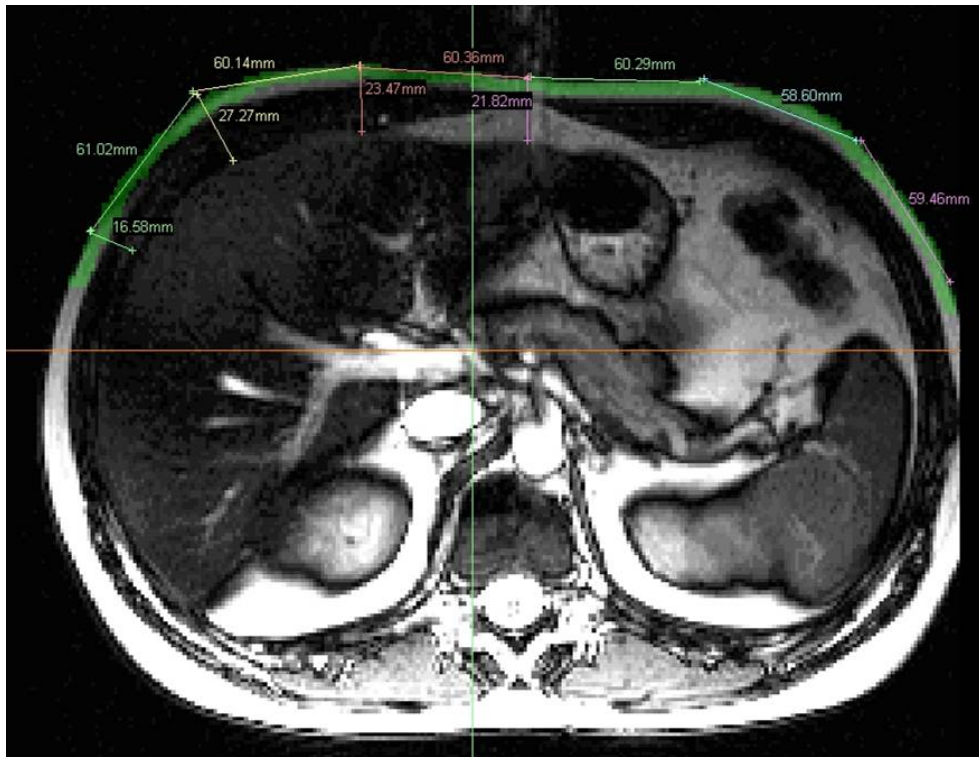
Typical MRI Image and analysis thereof
